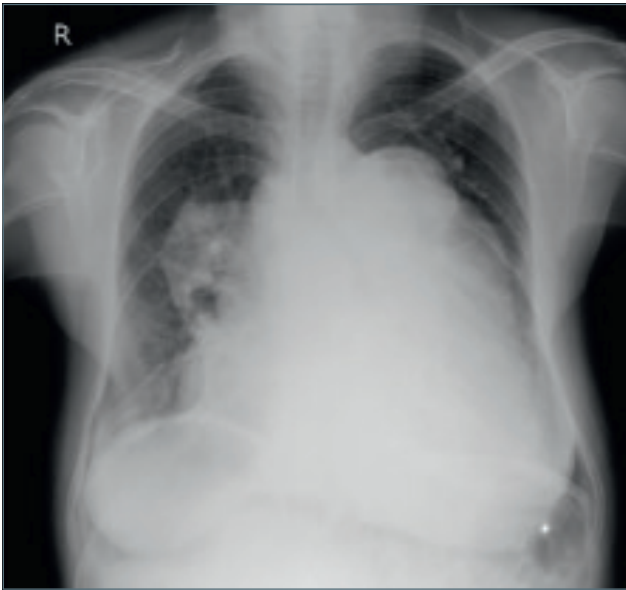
Showing massive cardiomegaly on chest x-ray PA view.
